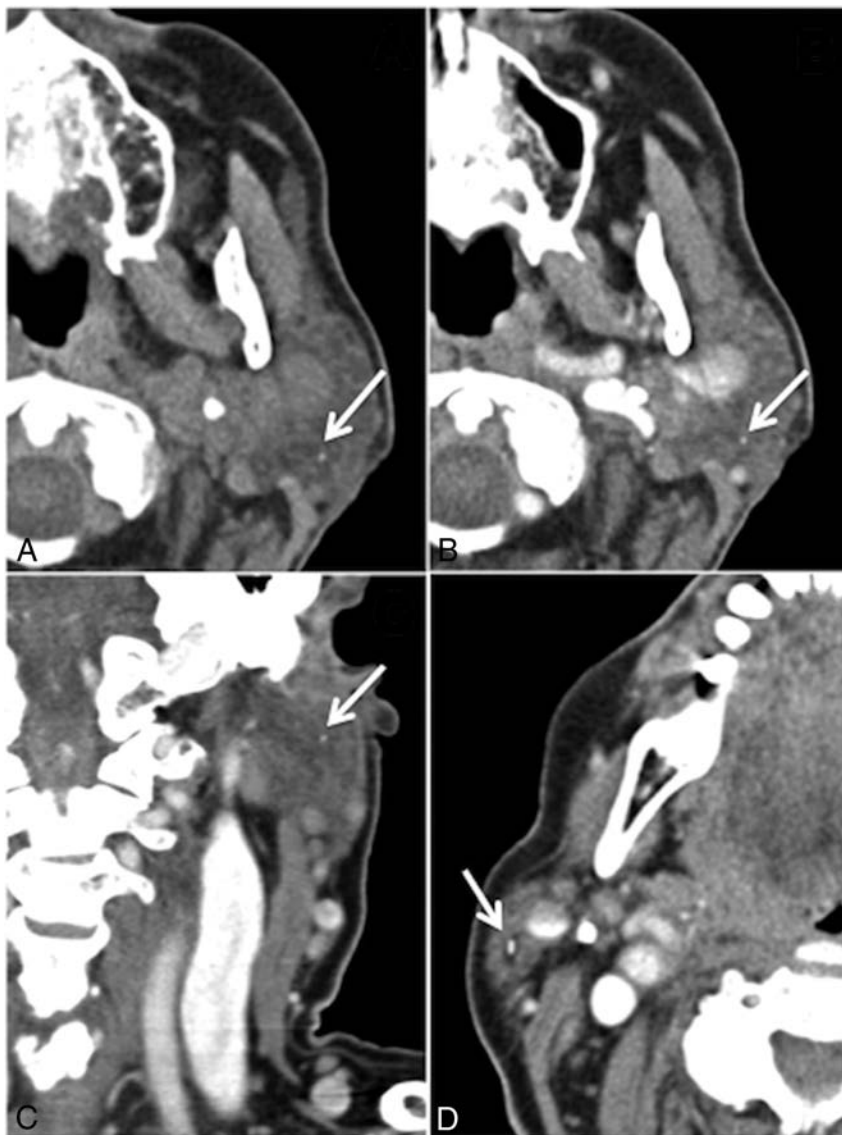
False-negative case. A, Noncontrast CT shows a 1-mm calculus in the superficial lobe of the left parotid gland (arrow), missed on initial review of the CECTN, though it is present on axial (B) and coronal (C, arrows) reconstructions. The distraction is an obstructing 3-mm calculus in the right parotid gland (D, arrow). Note the surrounding intraglandular ductal dilation.
